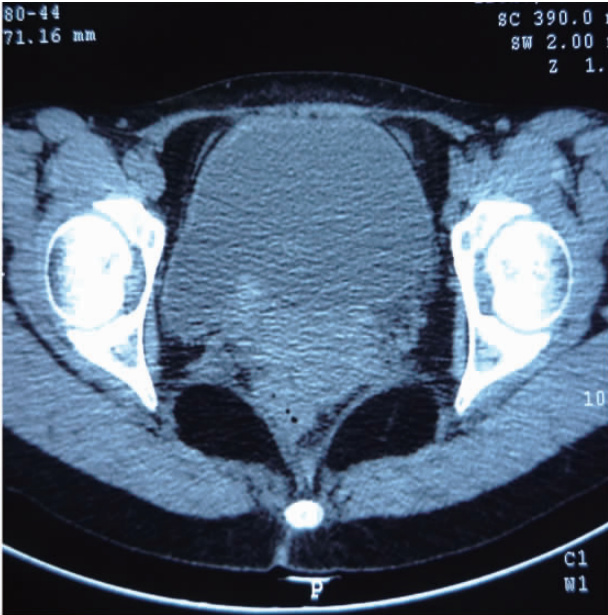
CT 示右侧输尿管开口处可见一占位病变突入膀胱 箭头所示
